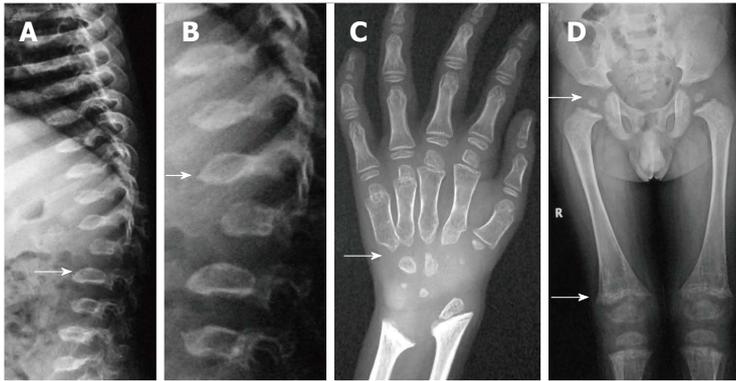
Morquio's syndrome. Radiographs of spine (A, B) show platyspondyly with maintained intervertebral disc height (arrow, A) and central beaking (arrow, B). Radiograph of hand (C) shows proximal pointing of metacarpals. Radiograph of pelvis and lower limbs (D) show delayed ossification of femoral heads, irregular epiphyses and secondary metaphyseal widening in proximal femur and around knee joint (arrows).
